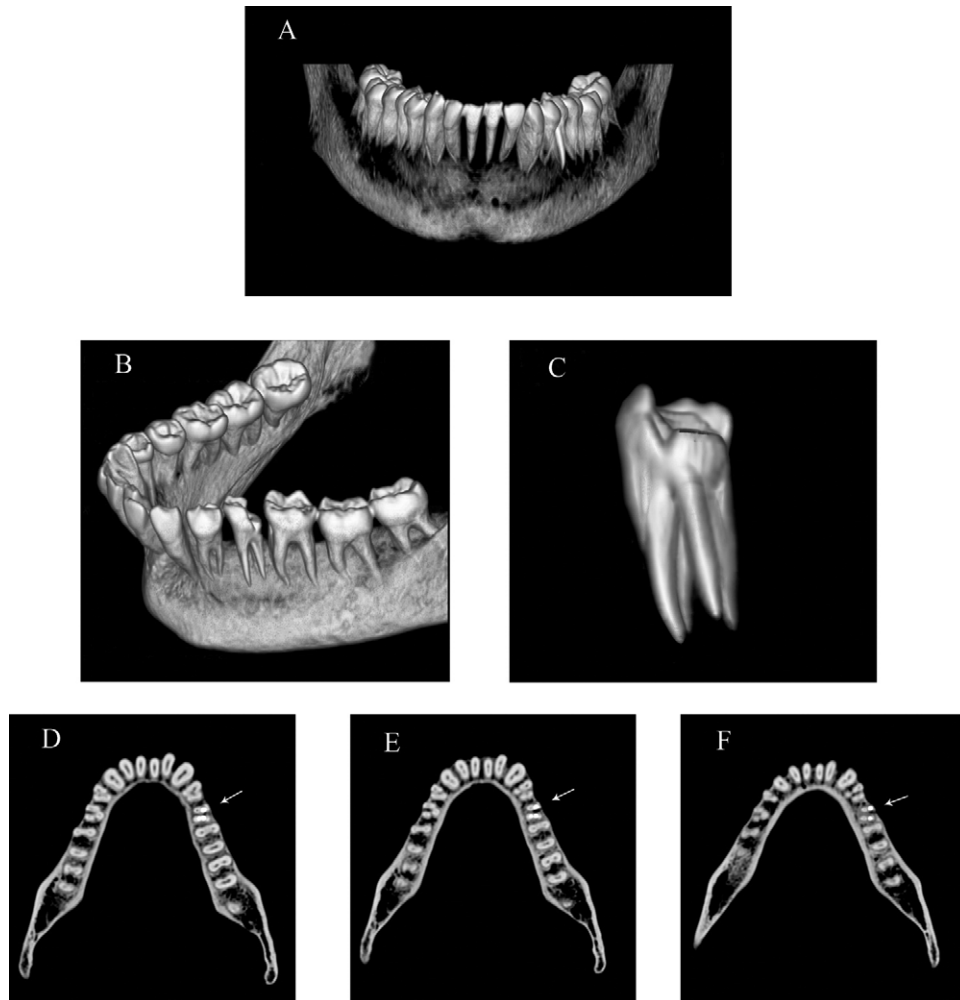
Spiral CT images. (A) Three-dimensional reconstruction of the mandible. (B) Three-dimensional reconstruction of the mandible (left oblique view). (C) Three-dimensional reconstruction of tooth #20. (D) Coronal third section of the roots of tooth #20 (arrow). (E) Middle third section of the roots of tooth #20 (arrow). (F) Apical third section of the roots of tooth #20 (arrow).
